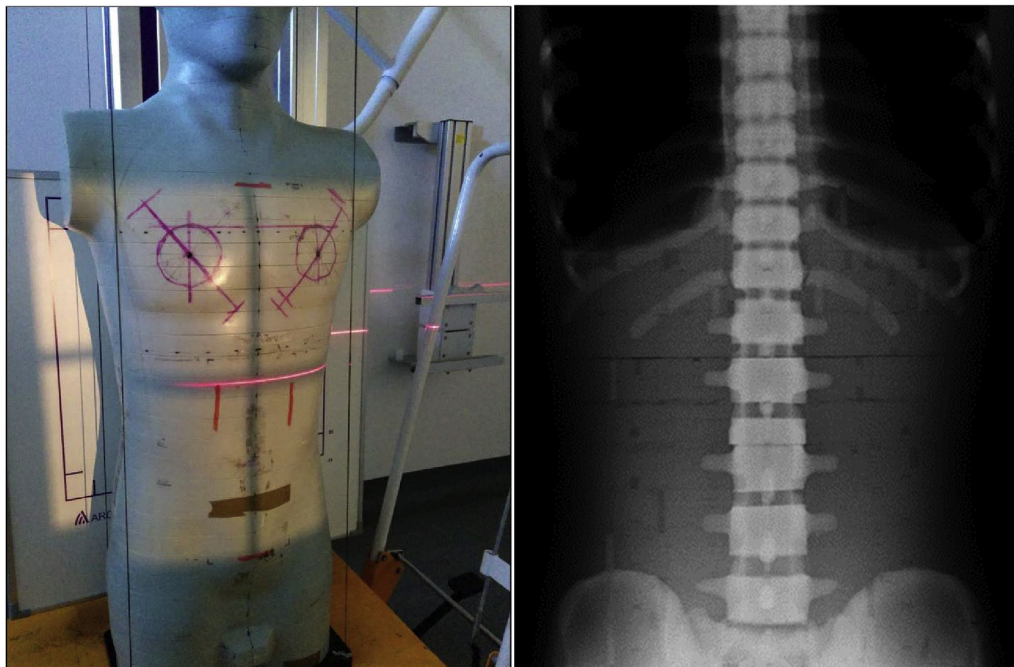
Photograph and radiograph showing extents of loose collimation.
